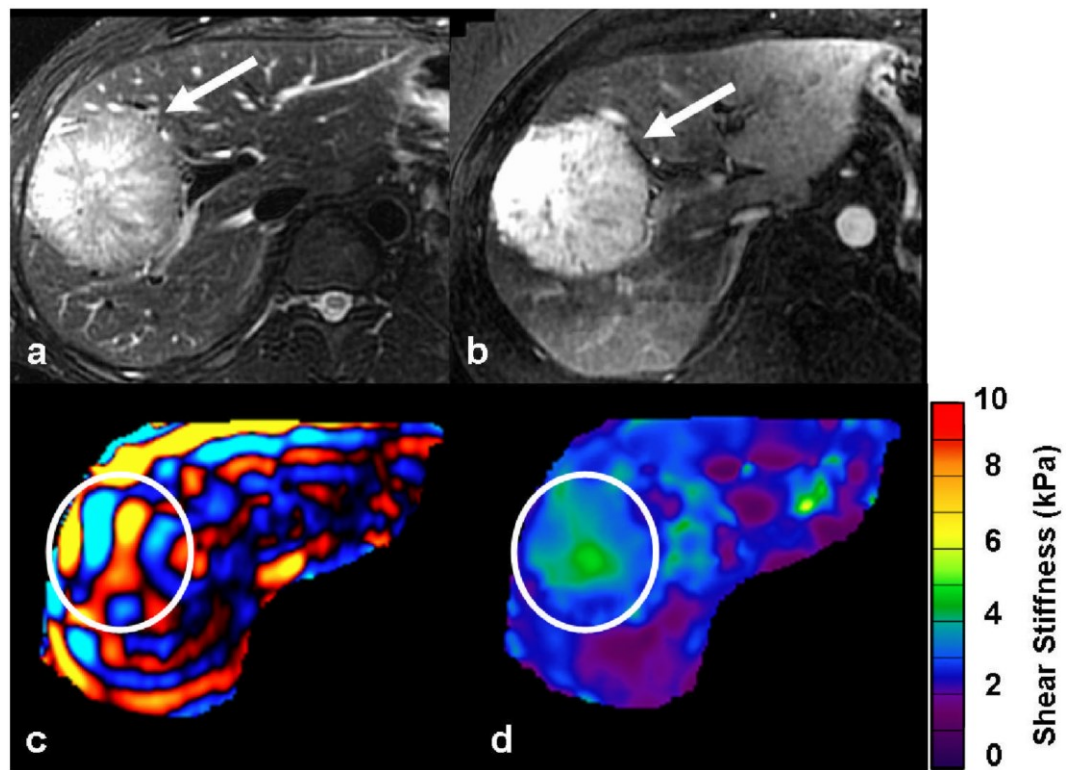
Incidental liver tumor (white arrow) is hyperintense on the T2-weighted image (a) and seen to intensely enhance in arterial phase of gadolinium enhanced T1-weighted image (b). Axial MRE wave image (c) showing good illumination of the tumor (ROI). Note that the waves in the tumor have slightly longer wavelength as compared to those in surrounding normal liver parenchyma. Elastogram (d) with ROI corresponding to the tumor. The shear stiffness value of the tumor was 3.1kPa and the surrounding liver, 2.4 kPa[16]
